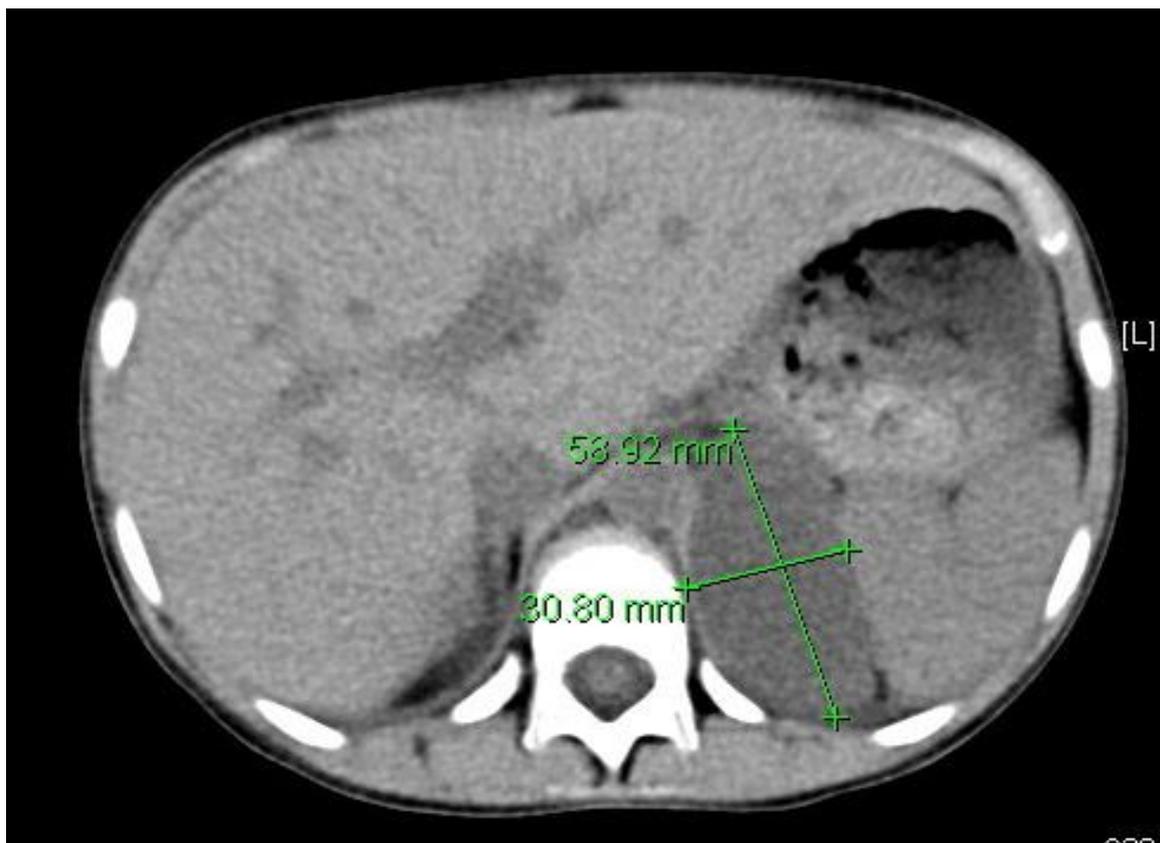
2 (a) Abdominal CT showed left adrenal mass measures 3.5 x 5.3 x 6 cm. no calcification, cysts or necrosis.
